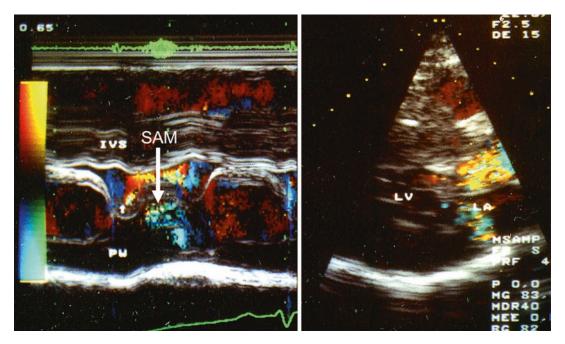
Colour flow Doppler superimposed to M-mode echocardiography (left) and long-axis parasternal view from a HCM patient. Note that the mitral regurgitation on the M-mode begins before the SAM-septal
